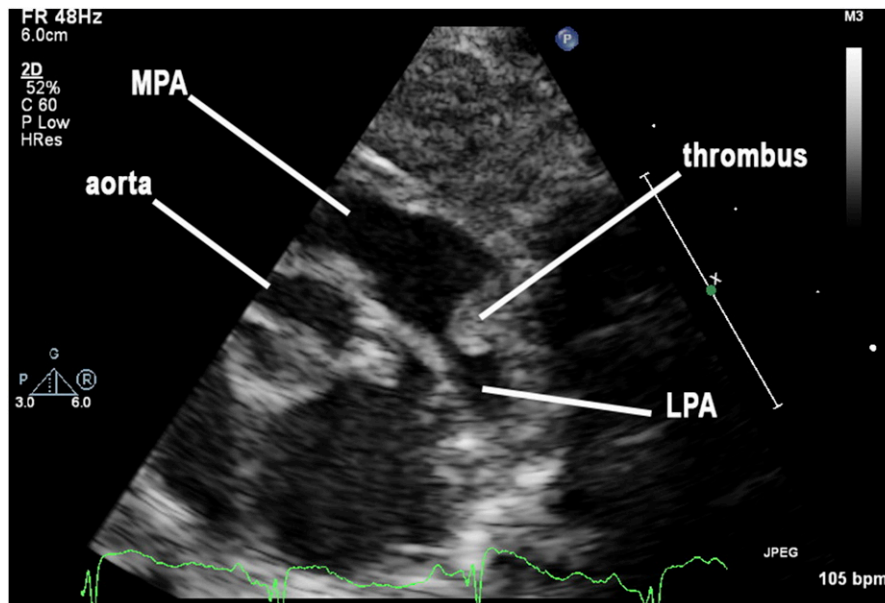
Echocardiographic parasternal short-axis view shows a cross-sectional image of the heart. Here the thrombus is protruding from the patent ductus arteriosus into the main pulmonary artery (MPA) and left pulmonary artery (LPA).
